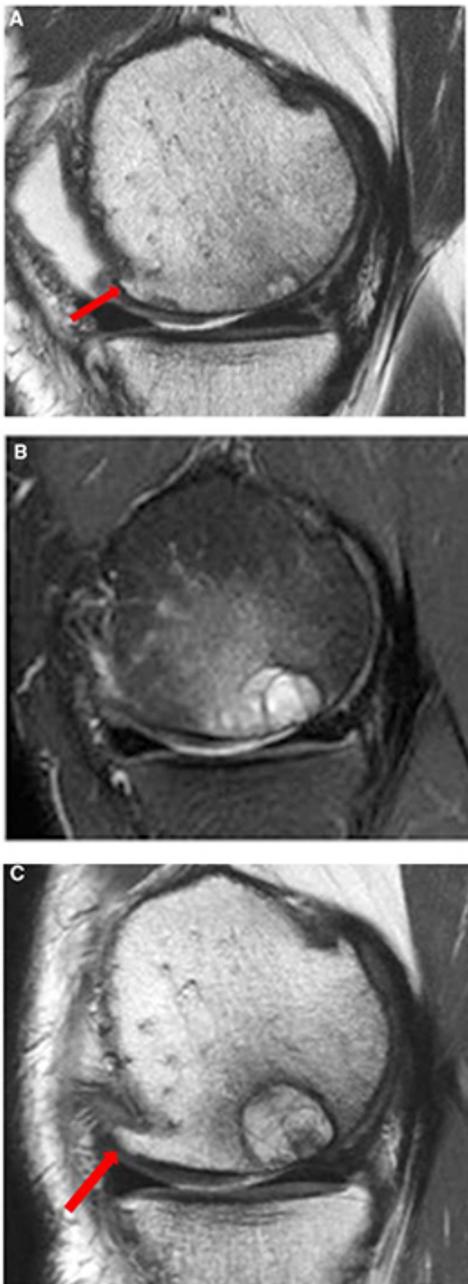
Sagittal fast inversion recovery and fast spin echo magnetic resonance images over the site of cartilage repair in a patient with osteonecrosis of the opposite femoral condyle. Persistent poor fill of the defect demonstrated by hyperintense repair cartilage is accompanied by a progressive subchondral cystic change and bone marrow edema. A, Three months after NeoCart implantation with adjacent osteophyte (arrow). B, Thirteen months after NeoCart implantation. C, Twenty-five months after NeoCart implantation. Osteophyte noted with arrow.
